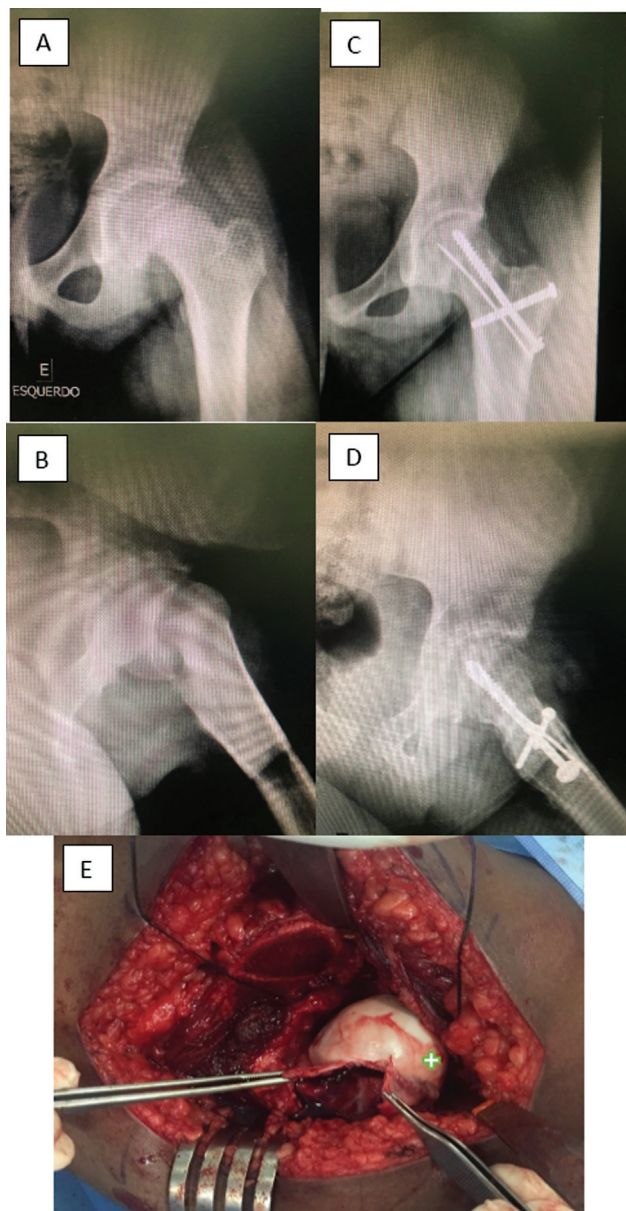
Radiographic aspect, preoperatively (A,B) and 27 months postoperatively (C,D), of a severe unstable slip with uneventful healing. Note: +Demonstrates the intact softspot, where retinacular vessels penetrating the epiphysis (E).
